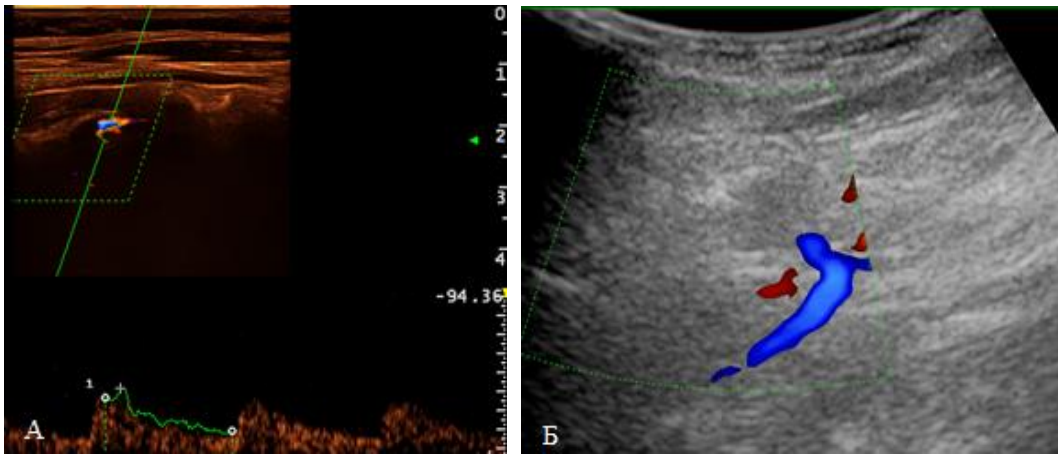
Doppler ultrasonography of the vertebral arteries Craniocervical department: A - visualization using a linear sensor, Б - visualization using a cavity sensor
